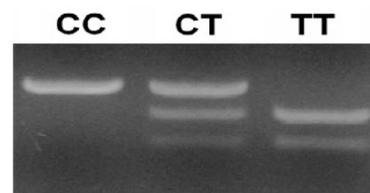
DNMT3b genotypes (CC, CT, TT) generated by AvrII restriction enzyme digestion.
